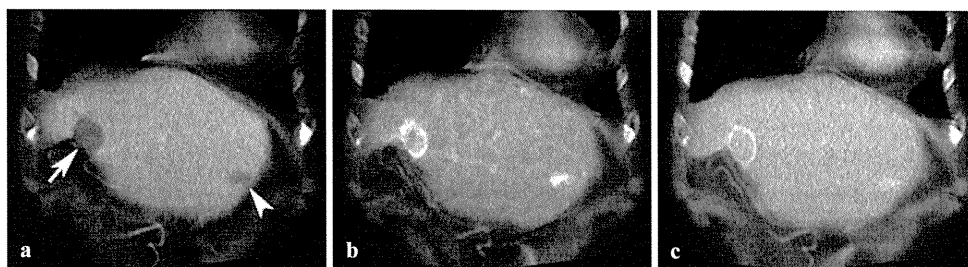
a Coronal view of CBCTAP image shows a round, hypoattenuating area (*arrow*) and an amorphous hypoattenuating area in segment III (*arrowhead*). b On CBCTHA, both lesions show enhancement. c On second-phase CBCTHA, the round lesion
